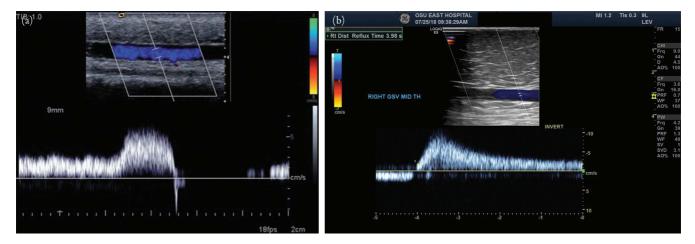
(a) Competent superficial vein. Well-optimized duplex image of flow in a competent superficial vein. Wide color box was used for a long segment of the vein to be visualized. Spectral waveform is large and clear. Spontaneous venous flow is seen in the left side of the spectral trace, followed by manual augmentation. There is a sharp "click" or "snap" of venous valve closure followed by a period of absent flow. Once arterial inflow refills the peripheral vascular bed, normal antegrade flow resumes again on the right side of the spectral Doppler trace. Adapted from Figure 1 of Necas M. Duplex ultrasound in the assessment of lower extremity venous insufficiency. *Australas J Ultrasound Med.* 2010;13(4):37–45. doi:10.1002/j.2205-0140.2010.tb00178.x. (b) Incompetent superficial vein. The reversal of flow last longer than 0.5 seconds after initiation of Valsalva.
